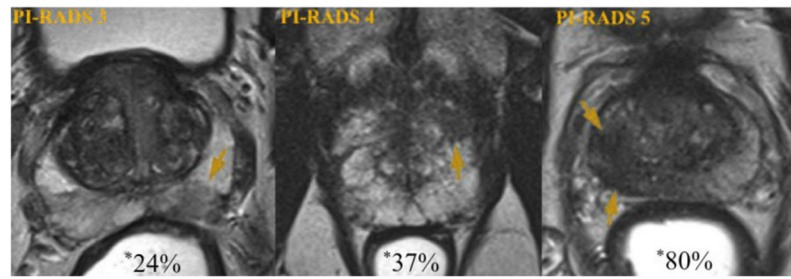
Likelihood of significant prostate cancer detection by MRI suspicion. Axial T2-weighted prostate images demonstrating peripheral zone lesions (arrows) of increasing suspicion. Examples are of a PI-RADS 3 target (left), a PI-RADS 4 target (center), and a PI-RADS 5 target (right). Percentages shown with asterisk represent likelihood of targeted biopsy revealing a cancer of Gleason Score 7 or greater, based on UCLA data ($n = 1,200$) (78). *Modified and reprinted with permission from *European Urology* 69(1); Weinreb et al. [19]. Copyright 2016, with permission from Elsevier. (Color version of figure is available online.)
